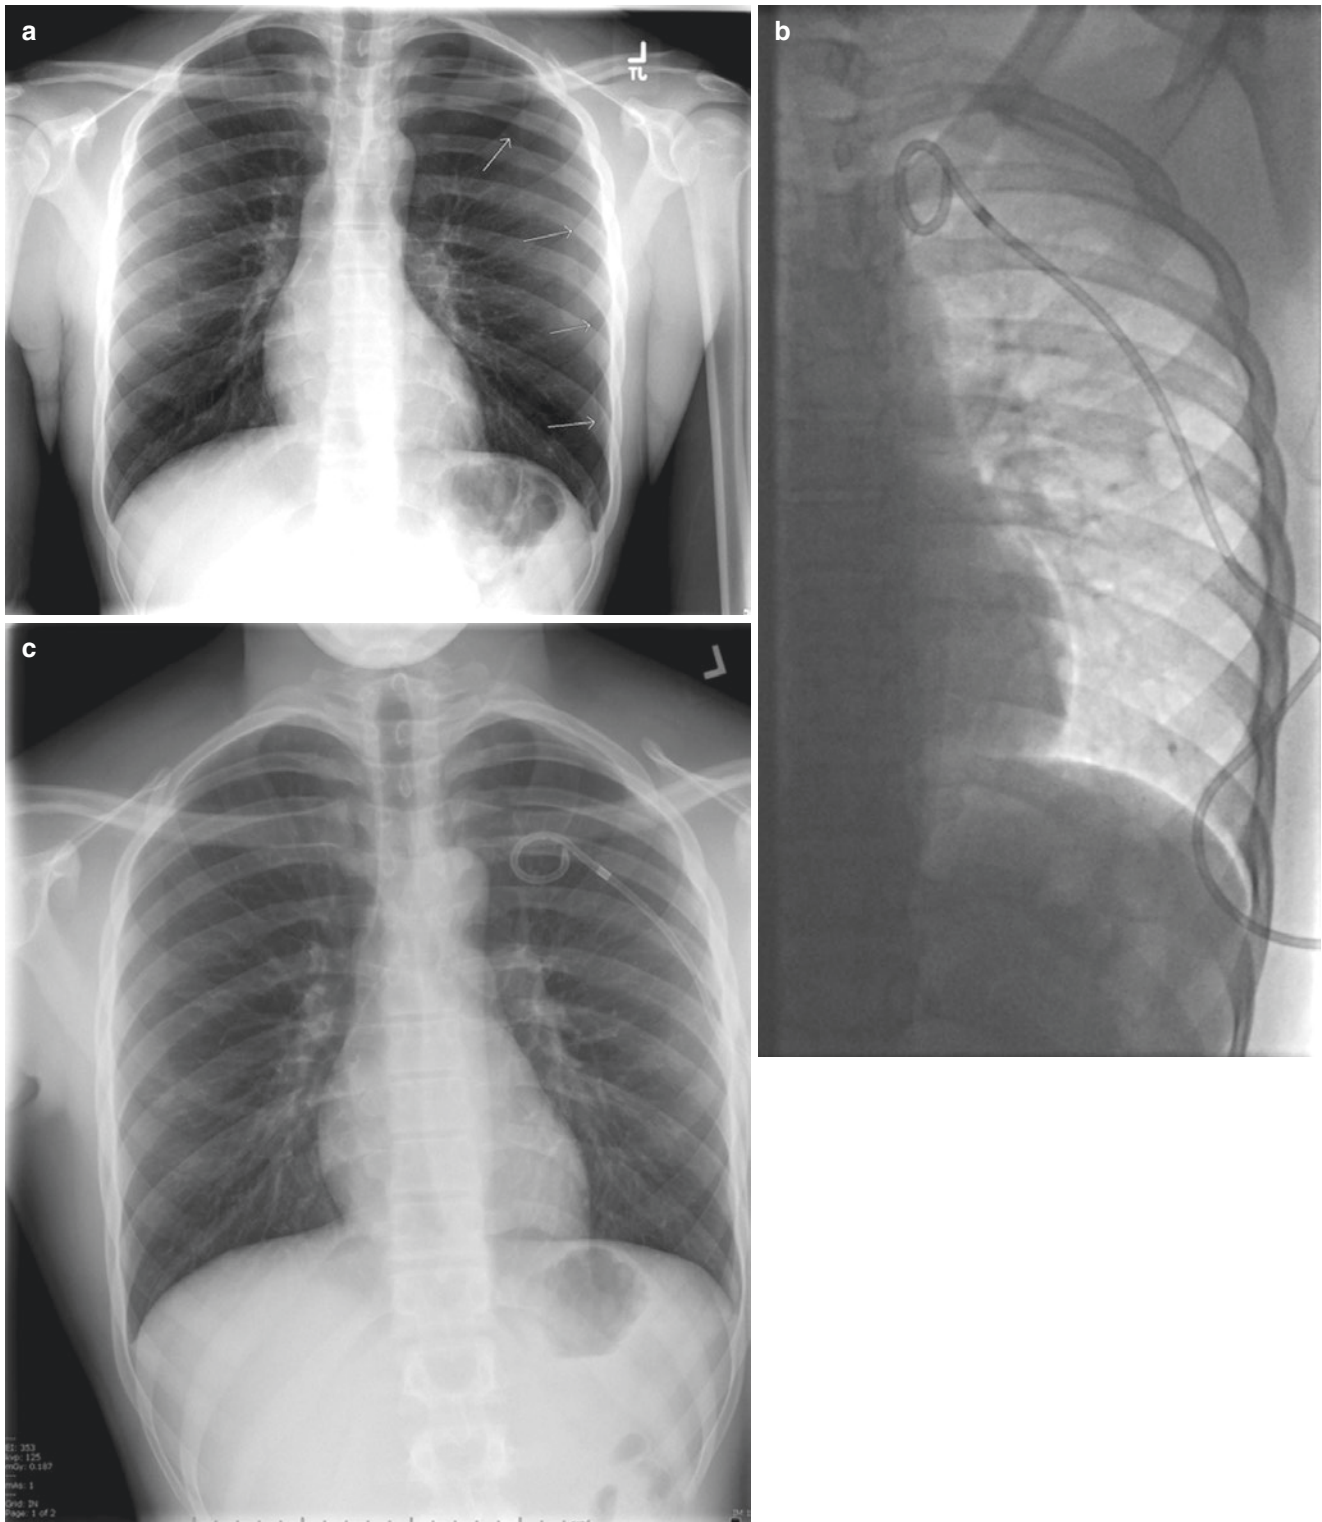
A 17-year-old patient presented to the ED with acute onset of shortness of breath. A chest X-ray revealed a moderate left pneumothorax (a). The patient was brought to the IR suite, and an 8 Fr pigtail
